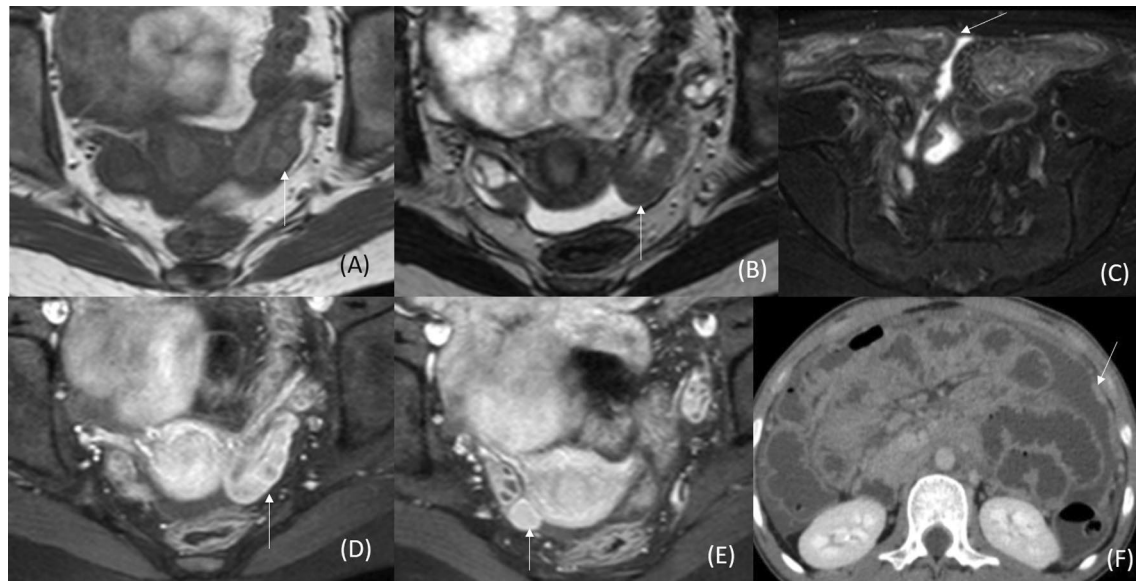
Female genital tuberculosis—bilateral fallopian tube involvement, ascites and peritoneal thickening. MRI pelvis of a 25-year-old-female shows dilatation of bilateral fallopian tubes with hyperintense wall on T1W image (A), wall is hypointense on T2W (B), free fluid in pouch of Douglas and endometrial cavity (B), T2 fat-suppressed image shows ascites (C), T1 contrast-enhanced images show peripheral enhancement of bilateral fallopian tubes (D, E), CT shows irregular peritoneal thickening (F)
